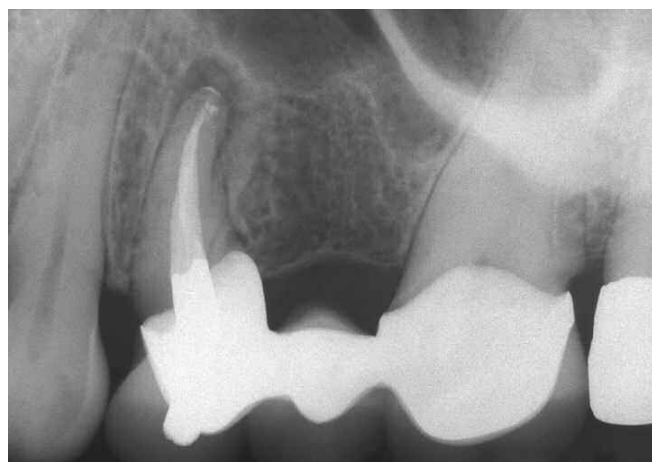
A post-treatment radiograph demonstrates complete endodontics. Note the pathway of the access through the crown to the underlying root canal system.
